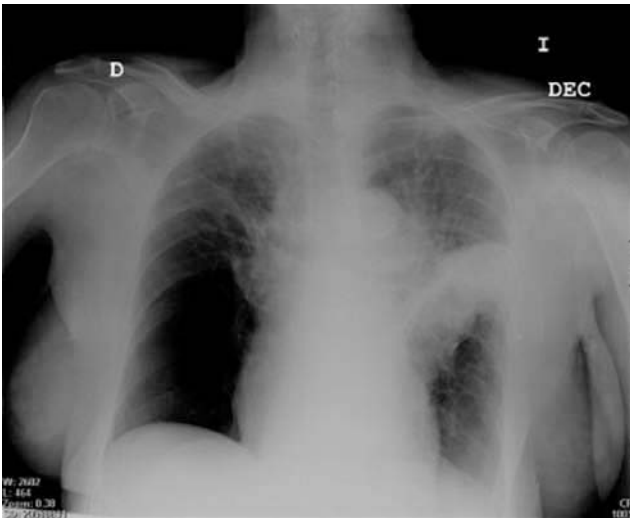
Posteroanterior thorax x-ray of the patient upon admission.
